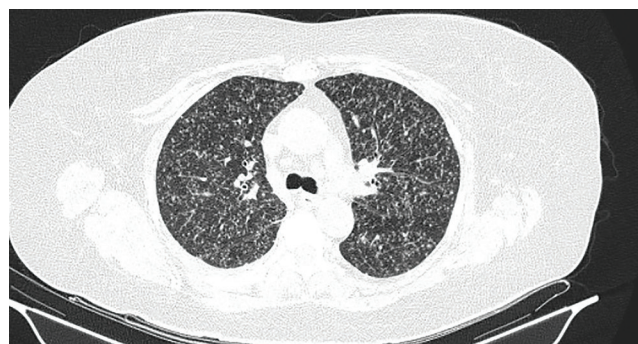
Computed tomography: multiple centrilobular “ground-glass” micronodules, disseminated in both lung areas, suggestive of pulmonary tuberculosis-miliary form.
